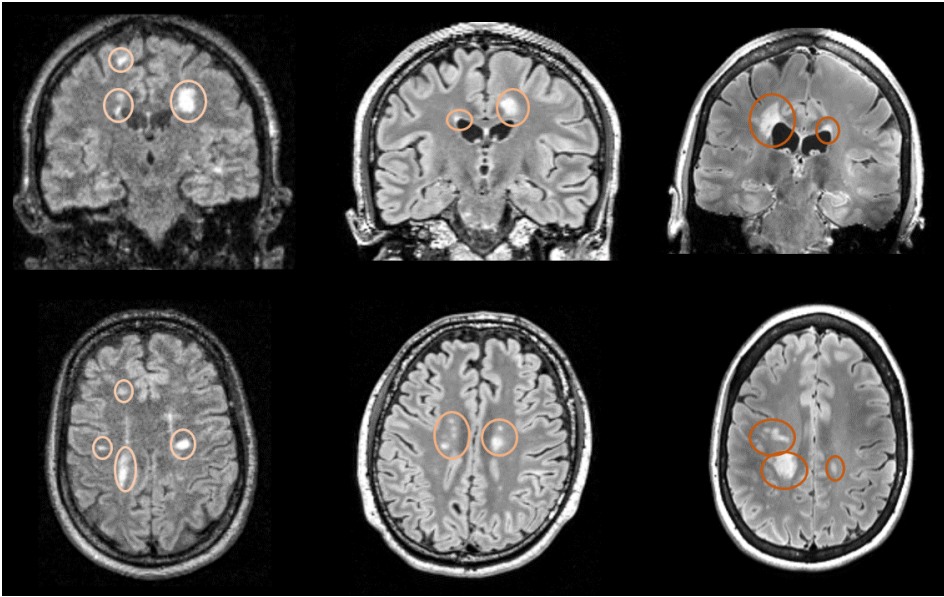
Example of three typical FLAIR images (up: coronal plane and down: axial plane), either acquired in clinics at 1.5T (left), or for research at 3T (middle) and 7T (right) for the assessment of MS disease. It can be seen that CSF signal is nulled (ventricles appear darker than the other tissues) while periventricular lesions look hyperintense. Images were acquired either in the CHU of Liège or in the Cyclotron Research Centre, Liège, Belgium. Circles highlight (major) lesions.
